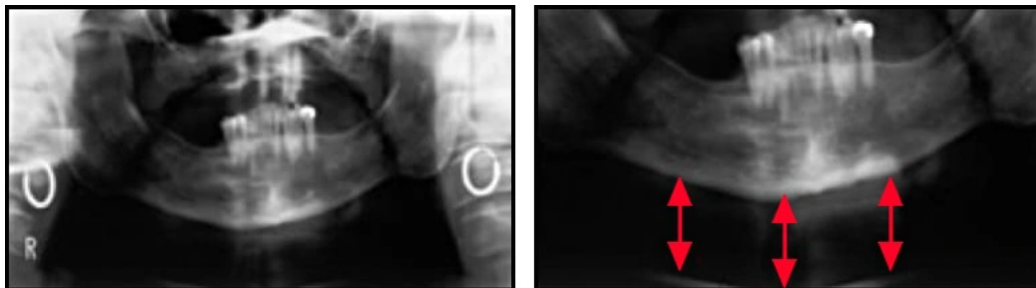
Panoramic radiograph (cropped and zoomed on right) demonstrating the effects of positioning the head off the chin rest. Note that in addition the patient is positioned too far forward.
